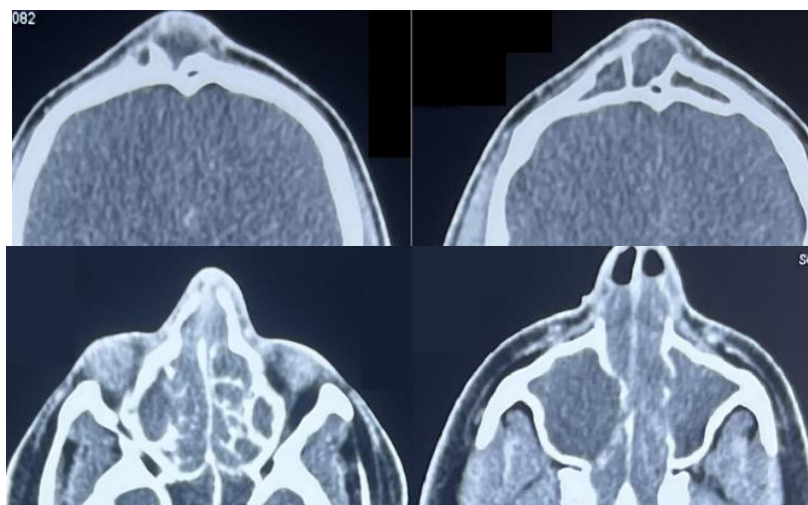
CT (axial images): frontal sinus opacification with anterior table bulging/erosion, and nasal cavity opacification due to polyposis
